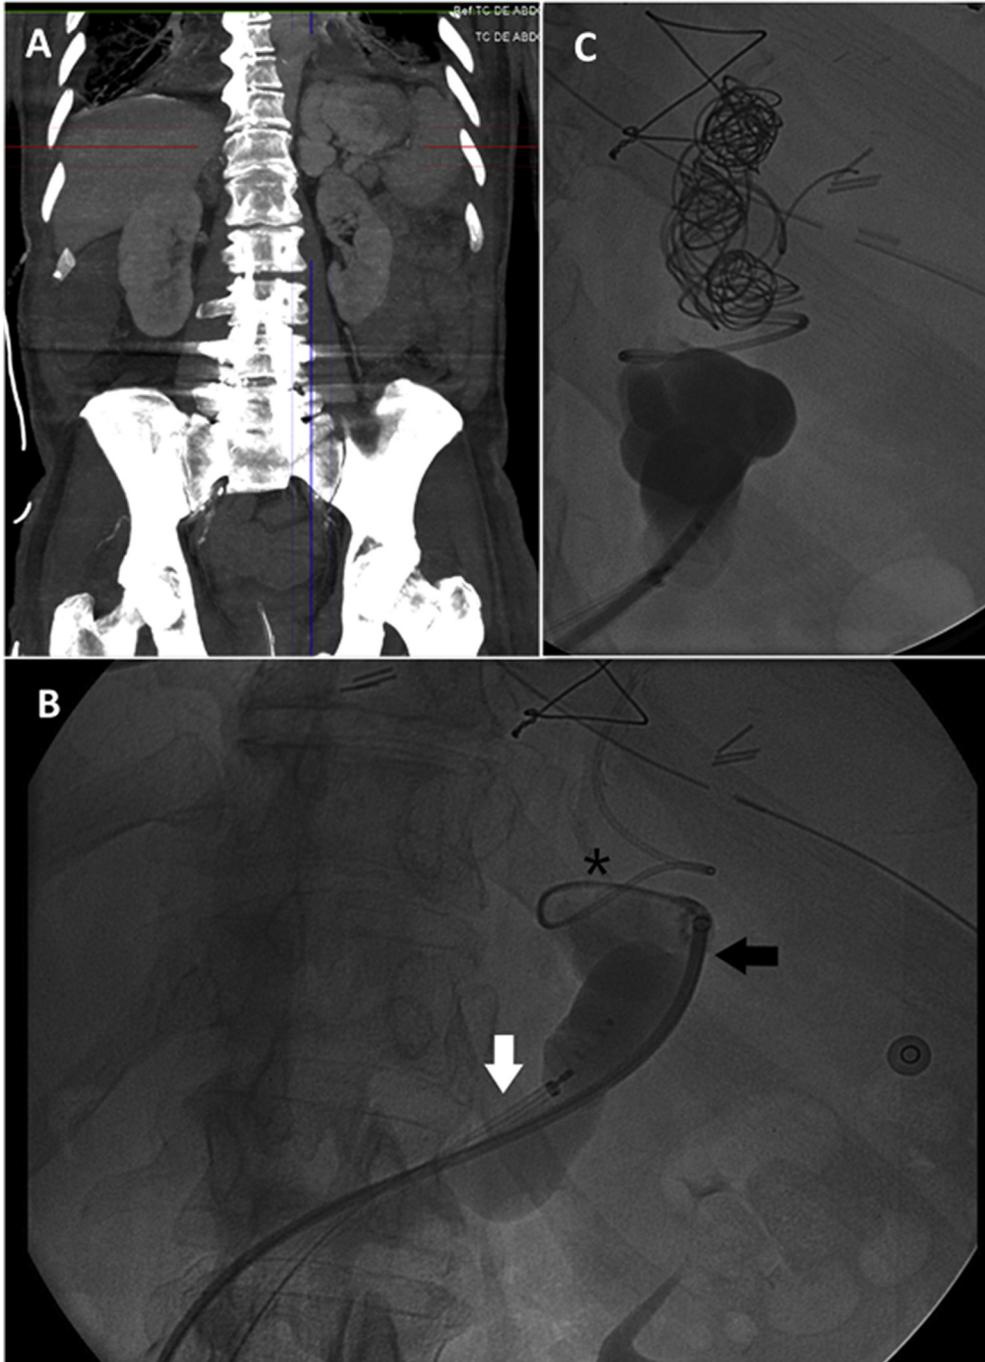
A. Coronal reformatted abdomen computed tomography before the intervention. Perisplenic collateral vessels are prominent above the left kidney. B. Fluoroscopic image of the BRTO intervention. A double sheath in the gastrosplenic shunt is inserted through the femoral veins. One sheath is in proximal position (black arrow) and a microcatheter is used for coil deployment (asterisk). The other sheath is in distal position (white arrow); a vascular plug is inserted for embolization. C. Fluoroscopic image. After proximal embolization with coils and distal embolization with vascular plug a venography is performed to confirm complete occlusion of the efferent shunt.
